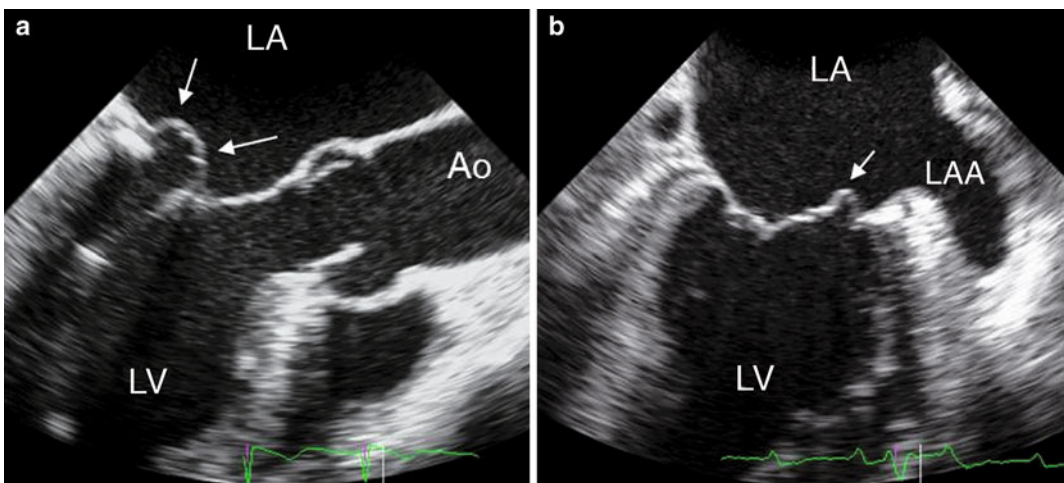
a Transesophageal long-axis slice showing prolapse of the central part (P2) of the posterior leaflet (arrows); b transesophageal two-chamber slice showing
